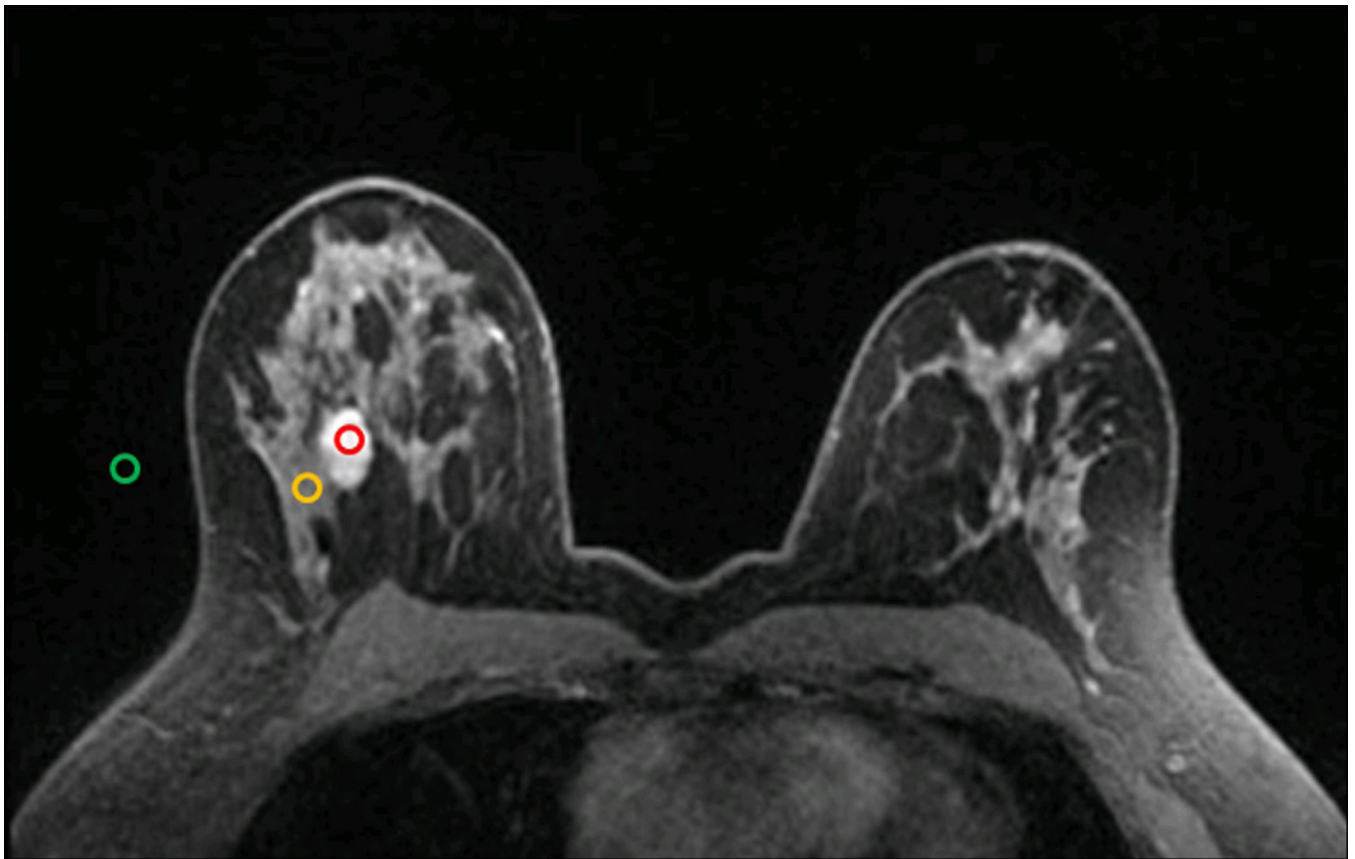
An axial image from a last set of TWIST DCE-MRI images, showing a contrast-enhanced tumor in the right breast. Three circular ROIs of equal size (6 pixels) were placed in the tumor region (red), non-enhancing normal parenchyma region (yellow), and background noise (green) for image signal intensity measurements.
